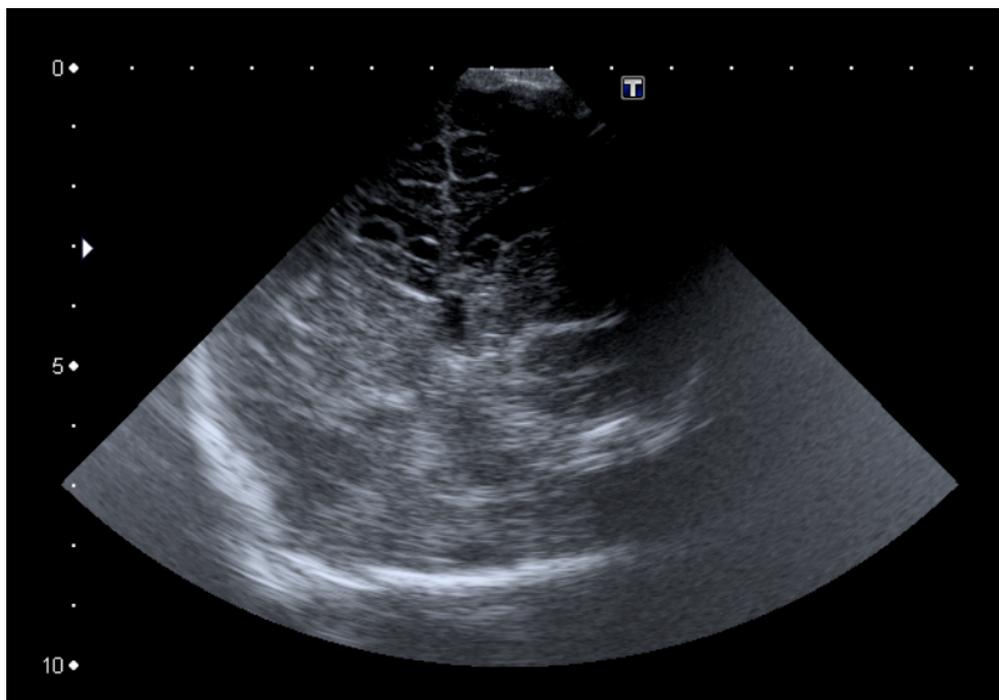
Cerebral ultrasound showed, at the level of both caudothalamicsulcuses, cystic sonographic appearance images compatible with germinal cysts of subependymal germinal and discrete enlargement in both lateral ventricles, mainly in the frontal horns.
